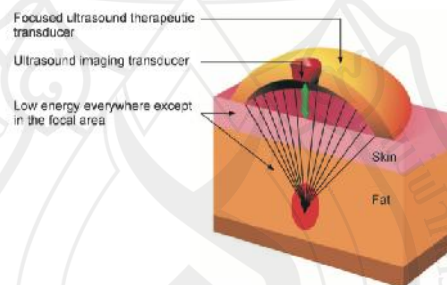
Focus Ultrasound Energy
